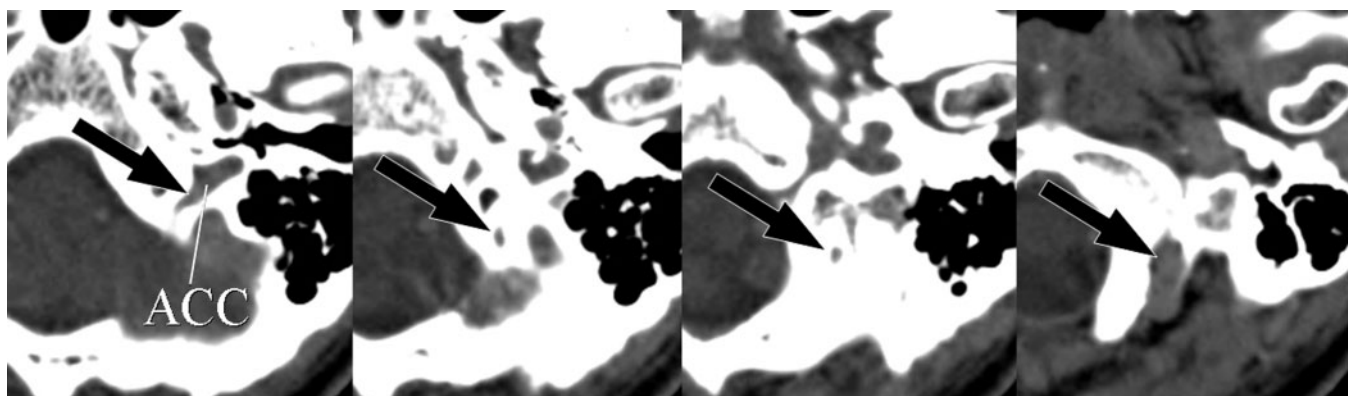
A 59-year-old female with intracerebral haemorrhage. Axial CT images show the posterior condylar vein originating from the anterior condylar confluence (ACC) and draining into the suboccipital cavernous sinus through the posterior condylar canal (arrows).
